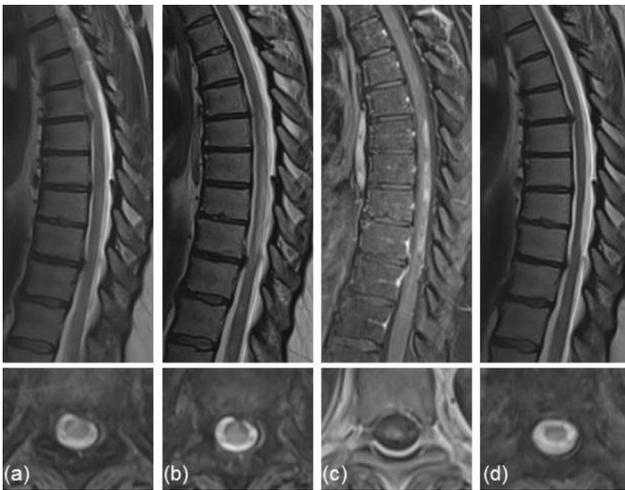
Evolution of MRI findings of spinal cord infarction in a patient with multiple sclerosis Fig. 1. Thoracic spinal cord magnetic resonance imaging (MRI) of the patient obtained on day 0, day 10, and 1 year following symptom onset. (a) Day 0. Faint T2-hyperintense signal from T6 through T8. (b,c) Day 10. Extensive T2-hyperintense lesion extending from T6 to the T10-T11 level (image b) with a linear craniocaudal strip of contrast enhancement (image c). (d) Residual atrophy of the spinal cord at the site of the lesion.
